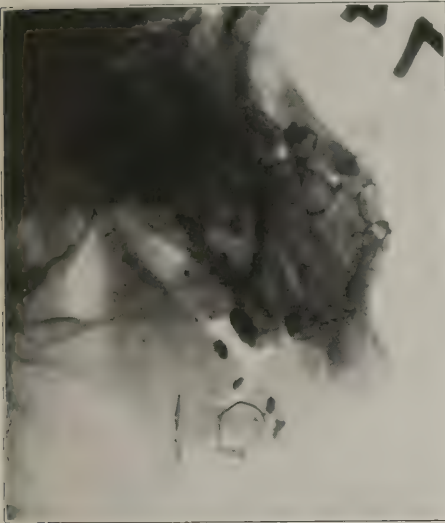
Case 1: Radiograph showing firm consolidation, three months after operation.
